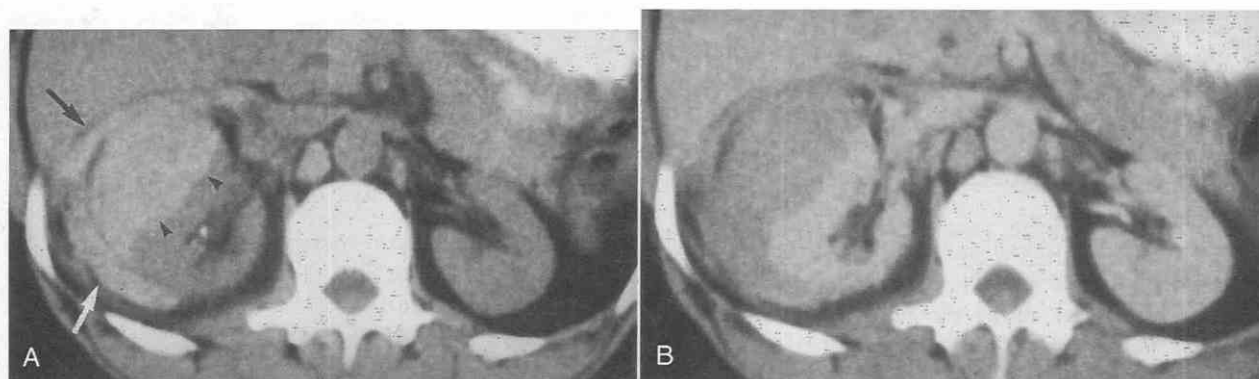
Right subcapsular and perinephric hemorrhage associated with idiopathic thrombocytopenia. *A*, An unenhanced CT scan shows indentation of the lateral border (*arrowheads*) of the right kidney by a denser subcapsular hematoma. A smaller perinephric hematoma (*arrows*) is also present. *B*, A contrast-enhanced CT scan shows that the hematoma is less dense than the enhanced renal parenchyma. (From Levine E, Grantham JJ, MacDougall ML: Spontaneous subcapsular and perinephric hemorrhage in end-stage kidney disease: Clinical and CT findings. *AJR Am J Roentgenol* 148:755-758, 1987.)
